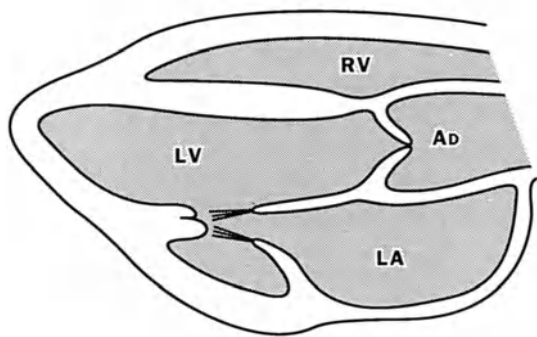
2D Echocardiogram: Long axis parasternal view.
